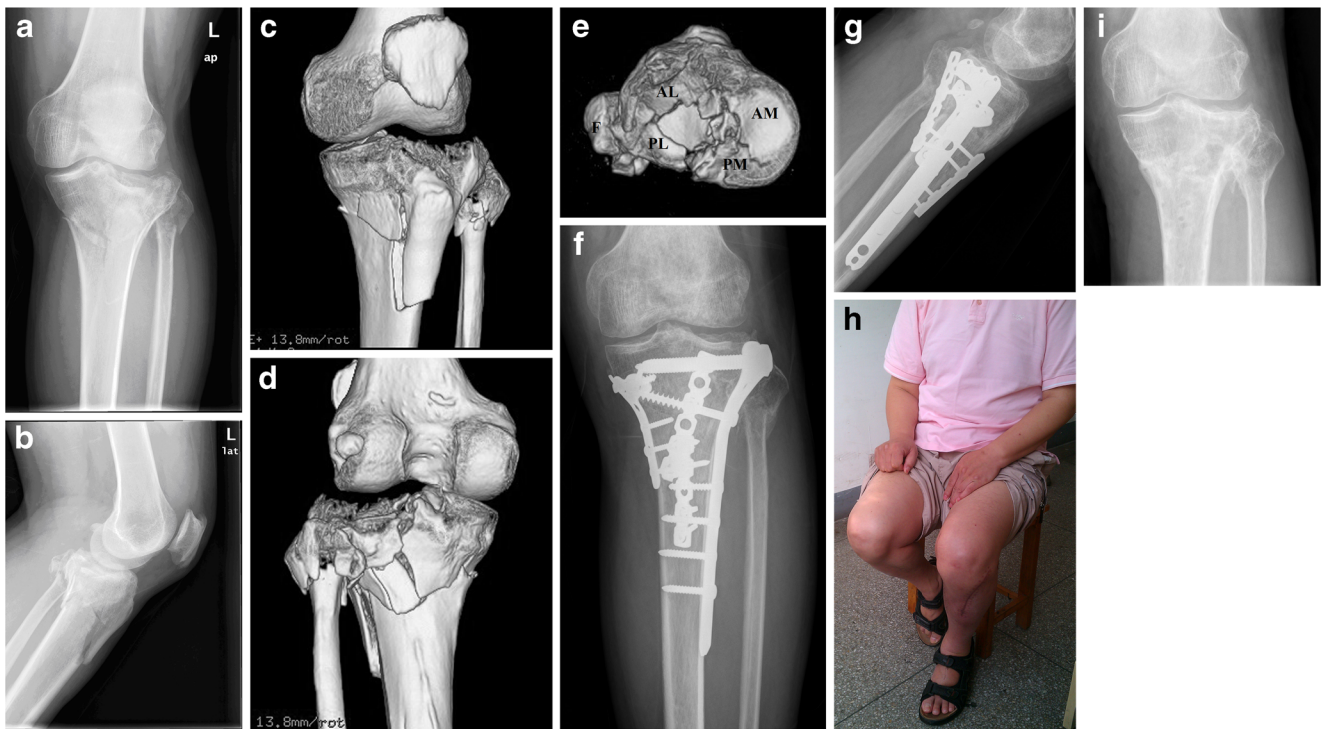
A 49-year-old male with bicondylar four-quadrant tibial plateau fracture. a, b Preoperative AP and lateral radiographs of fracture. c, d, e Preoperative 3D reconstruction showing a severe complex bicondylar four-quadrant fracture. Anterior, posterior, and superior views. f, g
